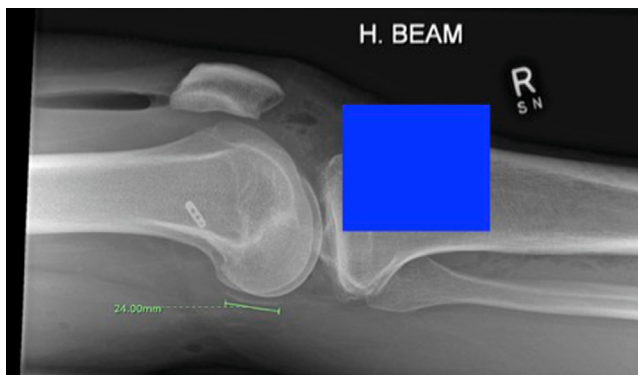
Lateral radiograph exhibiting severe (grade IV) bone debris (with exemplary length measurement (in millimeters) with tibial fixation blinding behind the superimposed blue square).
